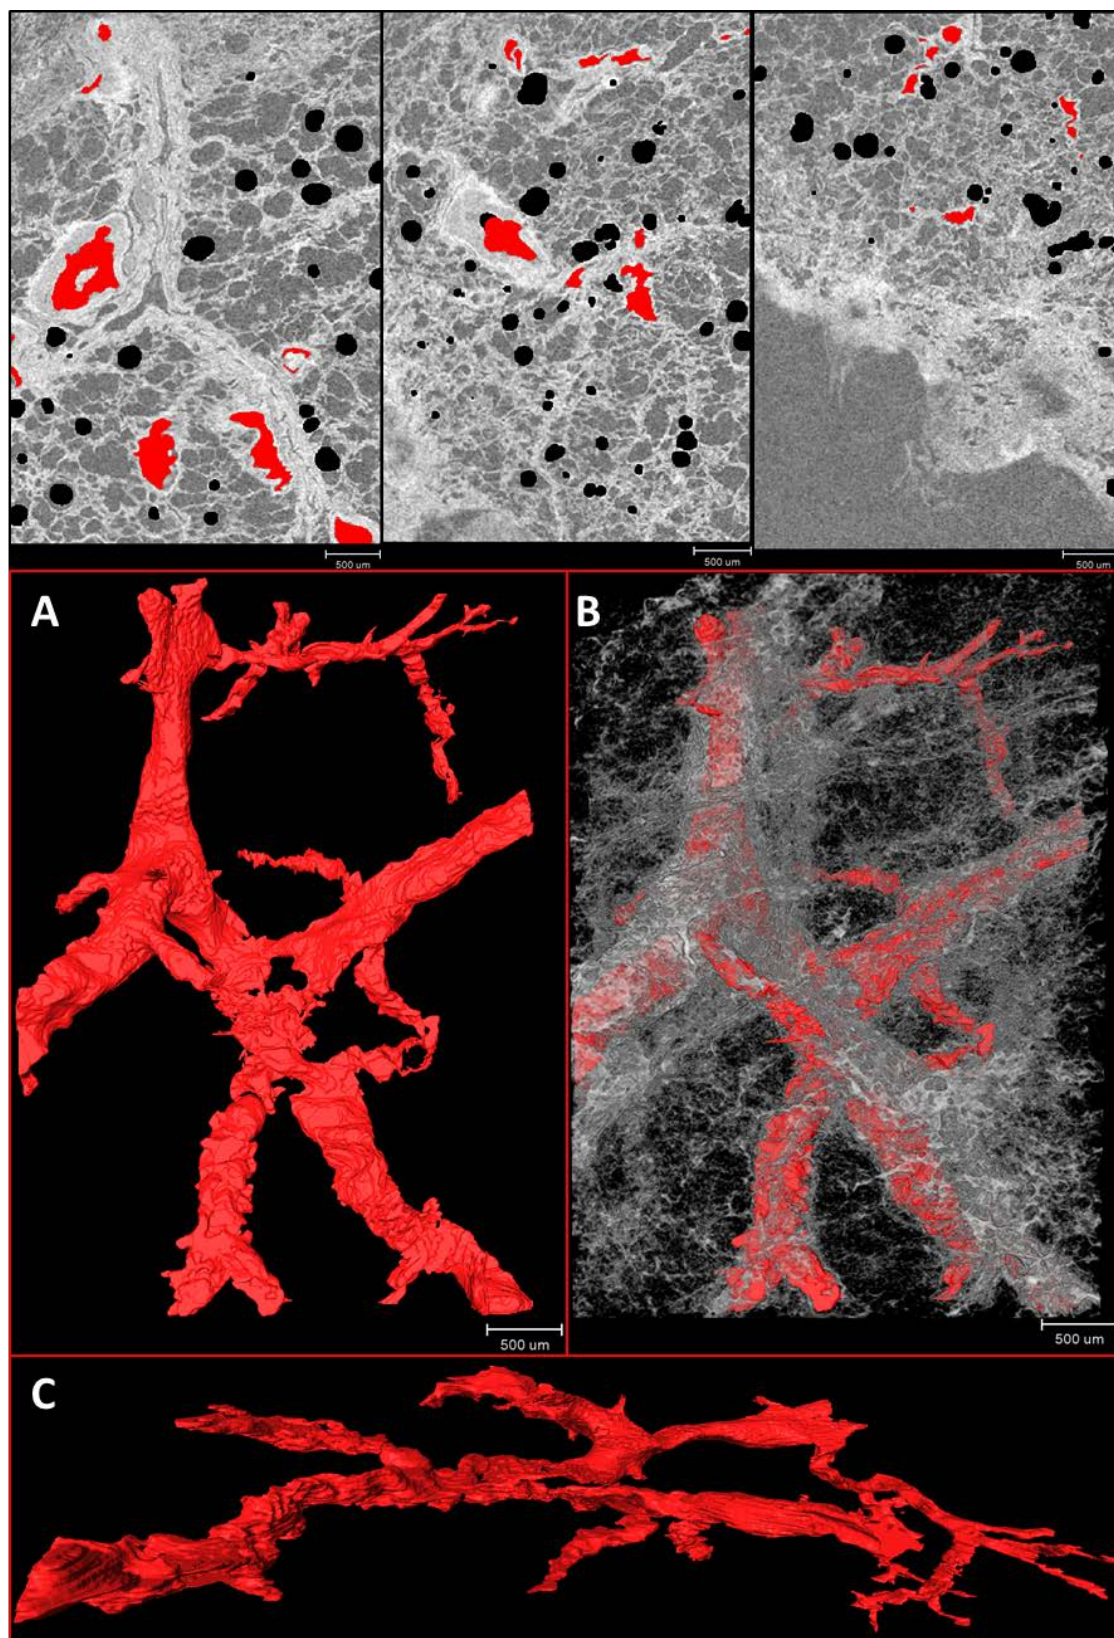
Manual blood vessel lumen segmentation visualised in 2D and 3D. The upper panels show the same representative  $\mu$ CT slices through the volume as figure 3.10 with the blood vessel lumen segmented (red). The lower panels show the manual lumen segmentation as a 3D surface render. This was visualised independently of the  $\mu$ CT volume (A and C) and also within  $\mu$ CT volume rendering (B).
